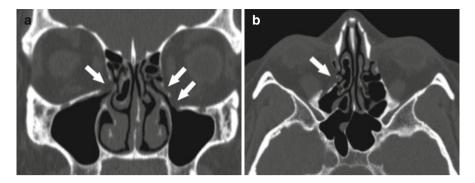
Coronal (a) and axial (b) CT images of bilateral accessory maxillary sinus ostia (*arrows*), just posterior and inferior to the native maxillary sinus outflow tract
